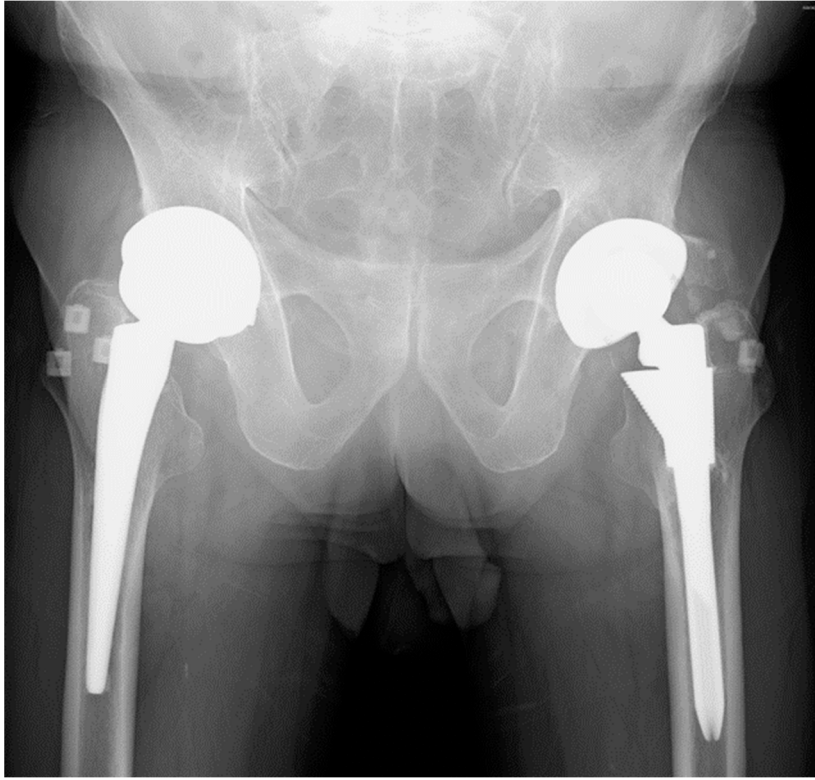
Radiographs of the both hips of a 71-year-old man.
